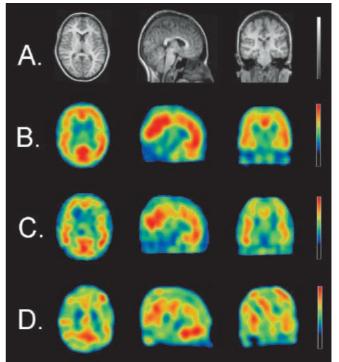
A MRI template showing transverse, coronal and sagittal sections. B–D Cerebral uptake of 5-HT_{2a} ligand ¹²³I-5-I-R91150 (transverse, coronal and sagittal sections) in healthy volunteers (B, mean image), deliberate self-poisoning (DSP) suicide attempters (C, mean image) and deliberate self-injury (DSI) suicide attempters (D, mean image)
